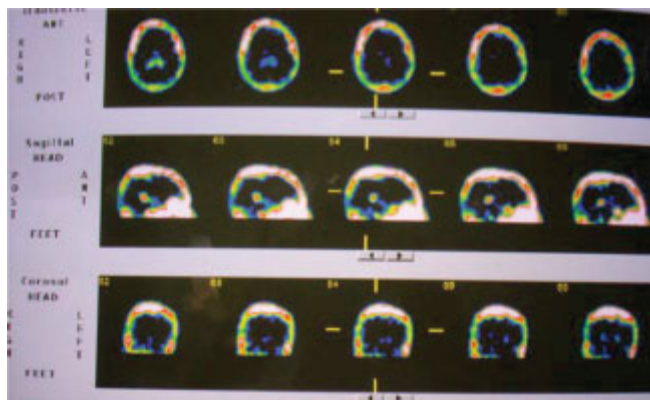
Tc-99m MIBI brain SPECT demonstrates lack of radioisotope uptake.
